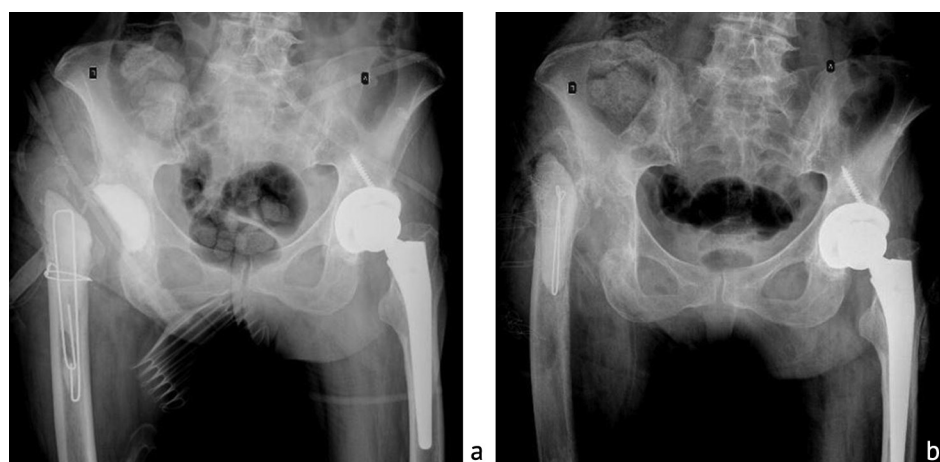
X-rays of the pelvis after debridement with the installation of an antimicrobial spacer: *a* X-ray after installation of the first spacer into the right hip joint; *b* X-ray after installation of the second spacer into the right HJ
